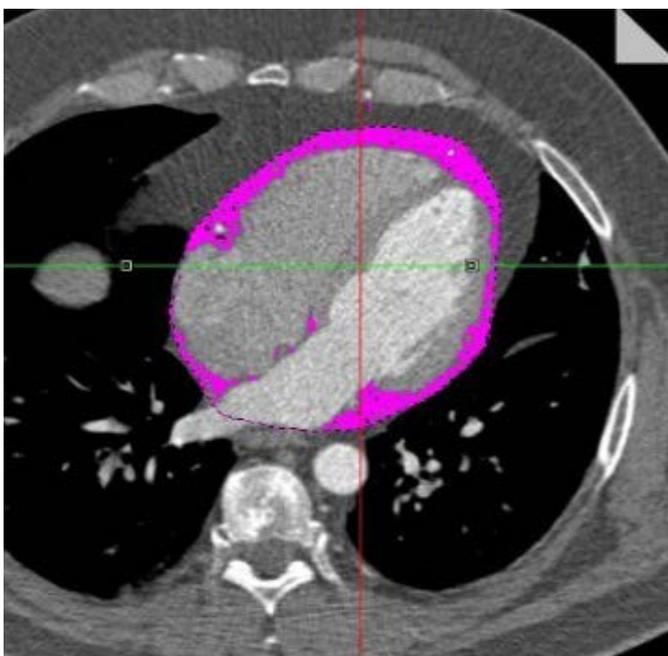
Epicardial adipose tissue quantification using native CT
